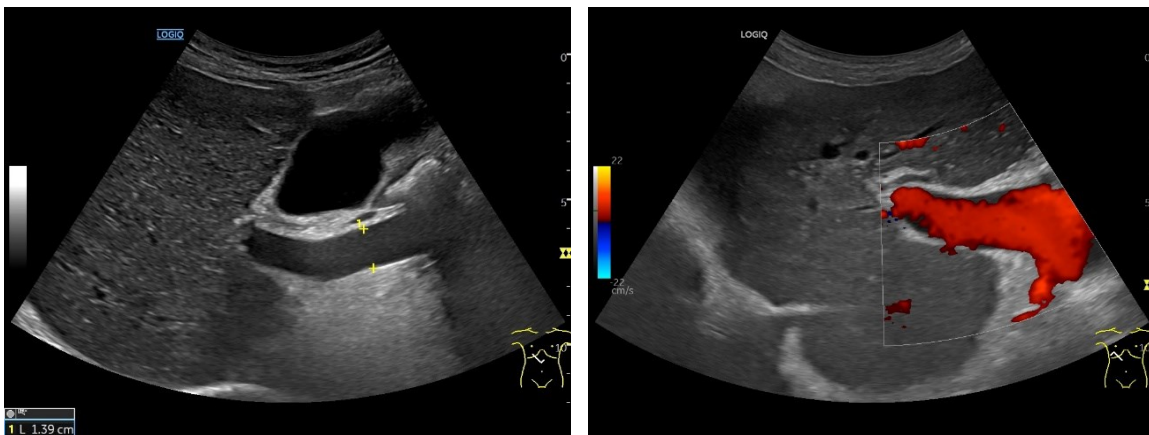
A-B. Evaluation of the Portal Vein (A) B-mode ultrasound demonstrating a portal vein diameter of approximately 14 mm at the hepatic hilum, suggestive of mild dilation.
